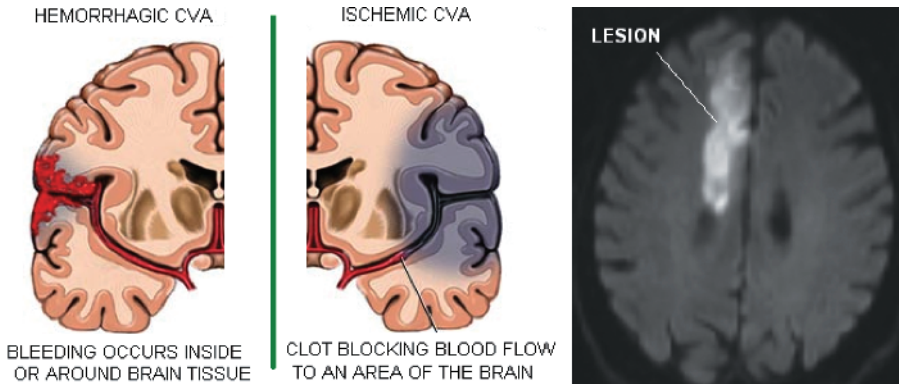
Sketch of the hemorrhagic (left) and ischemic (right) cerebrovascular accident. The right panel shows a magnetic resonance imaging (MRI) scan of a brain after an ischemic stroke.
